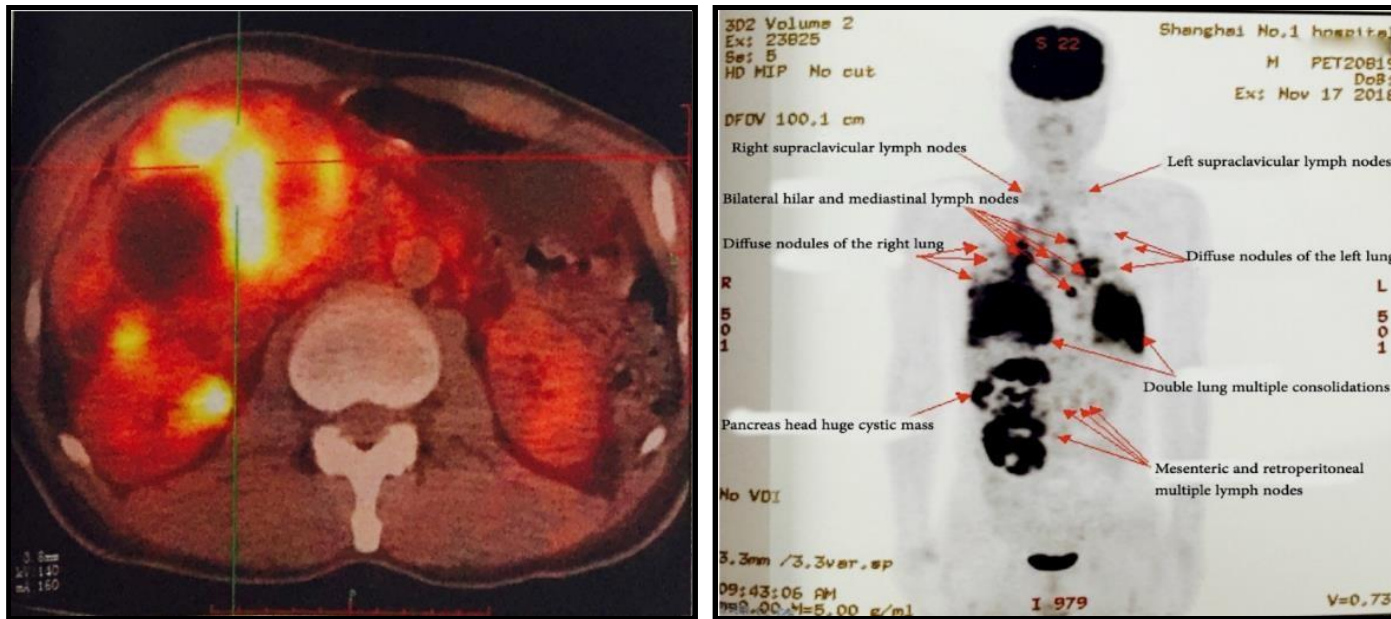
3B: PET-CT revealed a 10.9cm×7.7cm 17.9cm irregular multiple cystic masses with multiple papillary processes over the pancreatic head. The mesenteric, retroperitoneal, lung hila, mediastinum, right diaphragm, and bilateral supraclavicular lymph nodes were enlarged. Glucose metabolism activity of diffuse lung nodules, multiple lung opacity, and enlarged lymph nodes was extended in varying degrees.
